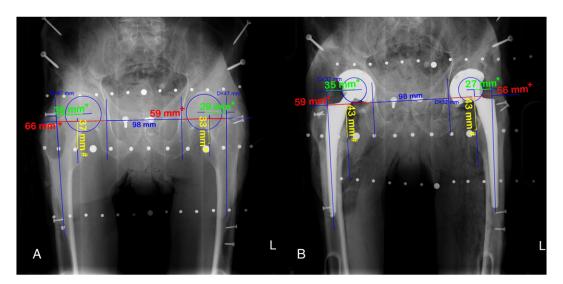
Change of LL (<sup>#</sup>), GO (<sup>+</sup>) and FO (<sup>\*</sup>) were assessed by comparison of magnification corrected preoperative (A) and postoperative (B) AP radiographs of the pelvis.
